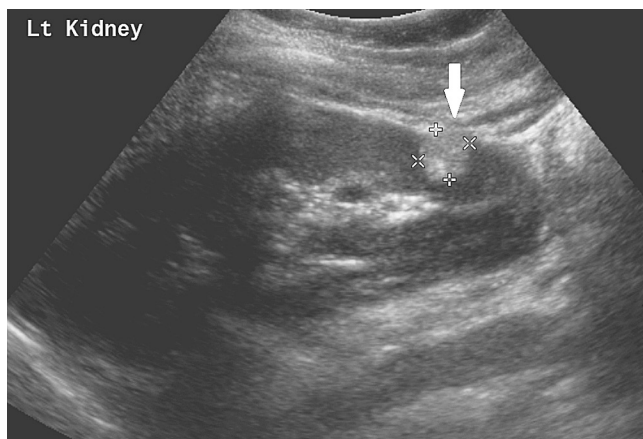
■ US of an angiomyolipoma. There is a small hyper-echoic mass in the lower pole of the kidney characteristic of an AML (see arrow). Confirmation of the diagnosis can be made with CT or MRI as small renal cell cancers may occasionally mimic the hyperechoic appearance of an AML.
